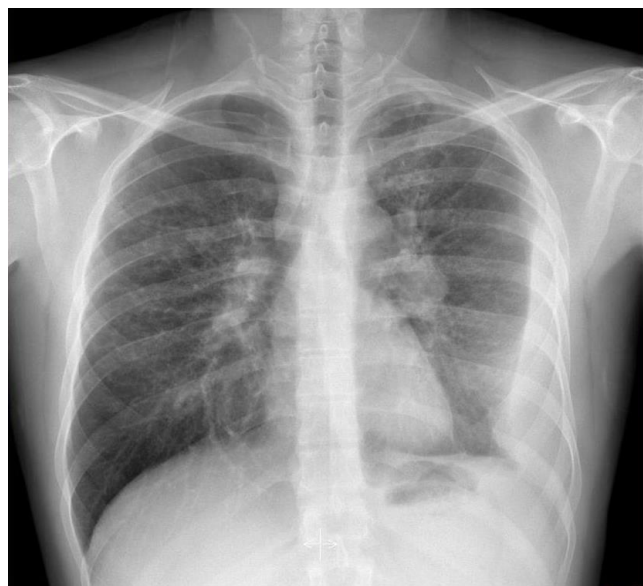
Posterior anterior chest X-ray revealed bilateral hilar enlargement, pleural effusion and parenchymal infiltration at the left upper zone.
